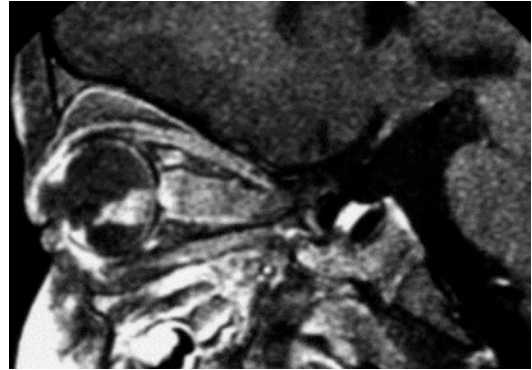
This sagittal T1 enhanced MRI images shows involvement of the optic nerve by tumor. (Public domain Wikipedia)
